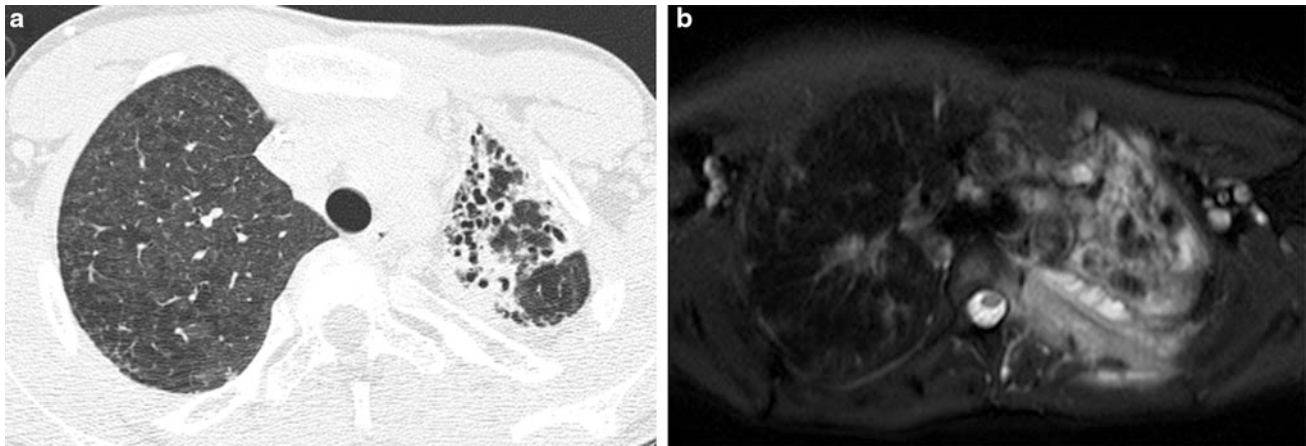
Chronic granulomatous disease (CGD). An axial chest CT image (a) from a 13-year old shows left lung volume loss and traction bronchiectasis from fibrosis related to CGD. An axial T2-weighted fat
